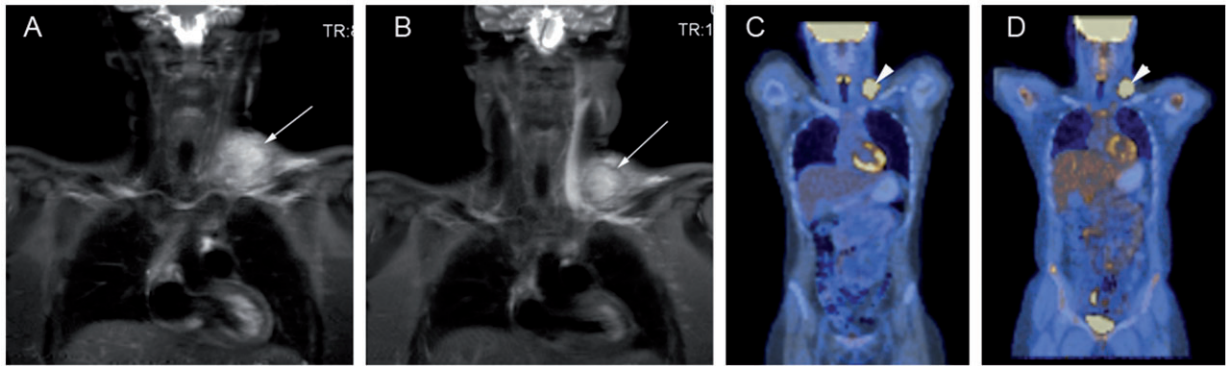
Coronal STIR MRI (TR 5.97, TE 60, TI 130 ms) and PET images of a patient with HL, before chemotherapy (A,C) and following 2 cycles of OEPa chemotherapy (vincristine, etoposide, prednisolone, doxorubicin) (B,D), showing a small change in size of a left supraclavicular nodal mass (long arrows), and inadequate metabolic response (arrow heads), with persistent PET positivity.
